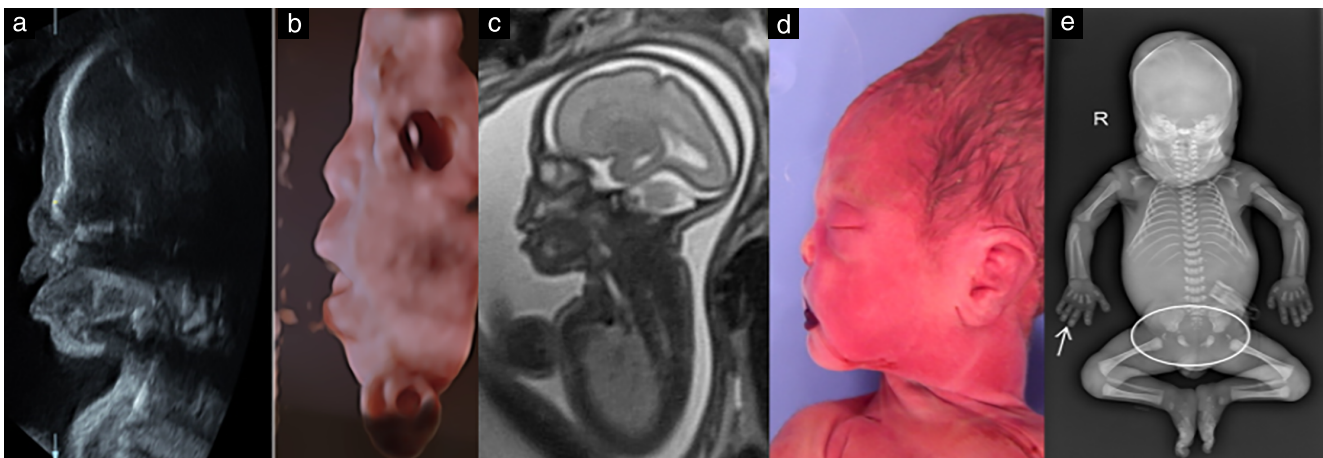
Facial profile of fetus with X-linked recessive chondrodysplasia punctata, as seen on two- (a) and three- (b) dimensional ultrasound, magnetic resonance imaging (c) and postmortem examination (d), showing flat nasofrontal angle and verticalized nasal bones typical of Binder phenotype. (e) Postmortem X-ray of same fetus, showing skeletal anomalies of chondrodysplasia punctata, including hyperechoic focal calcifications (puncta) on femoral epiphyses (encircled area) and brachytelephalangy (hypoplasia of distal phalanges of hands) (arrow). R, right.
